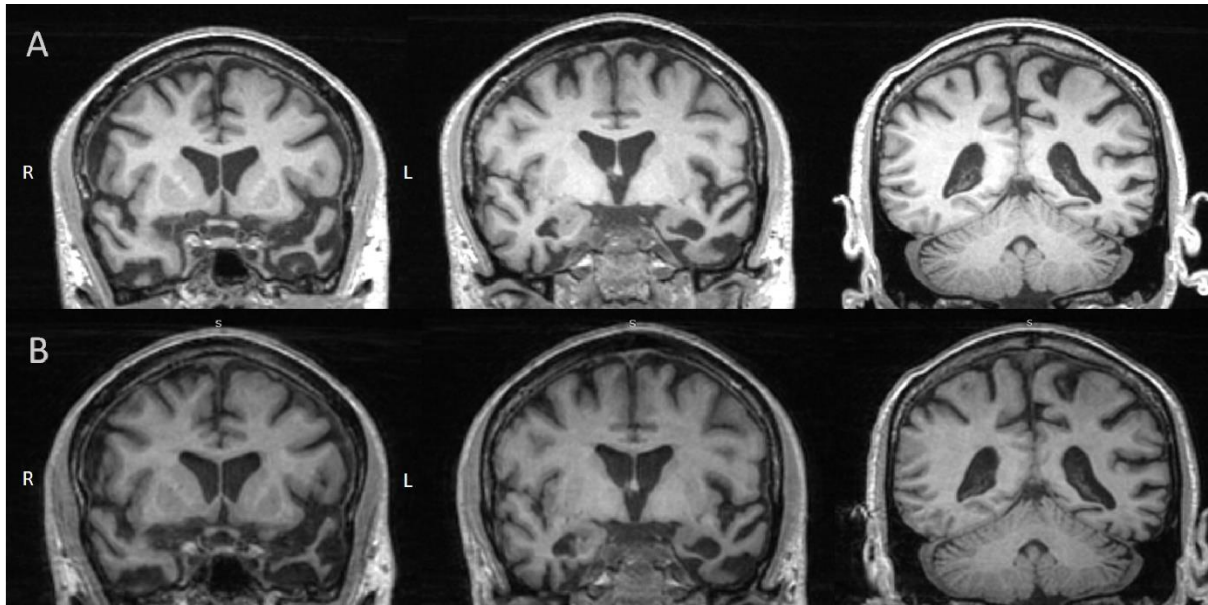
Coronal view of WR's MRI. These images demonstrate characteristic left anterior temporal pole grey matter atrophy consistent with a diagnosis of left-lateralised svPPA in Patient WR. Panel A displays WR's scan from his initial clinical visit in 2017, while Panel B shows WR's follow-up scan one year later in 2018.
